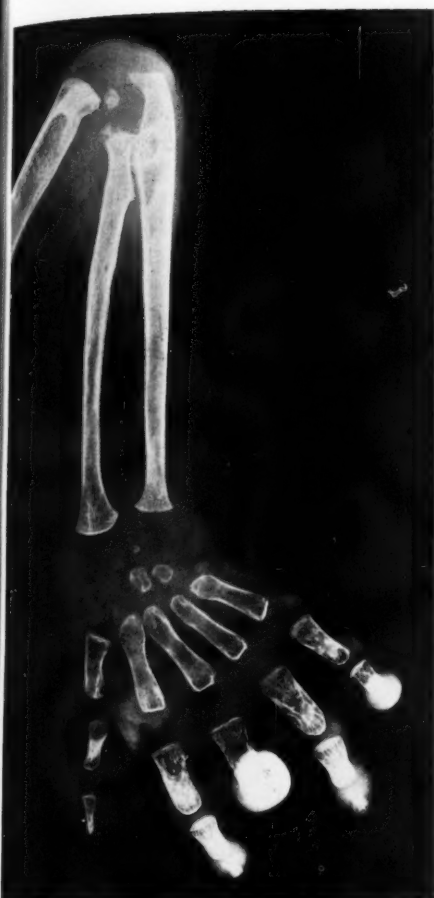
Roentgenogram of the right forearm demonstrating marked capsular distention of elbow, wrist, and interphalangeal joints by a substance of soft-tissue density. Note the subluxation of the elbow joint and grotesque deformity of the soft tissues of the right thumb.
